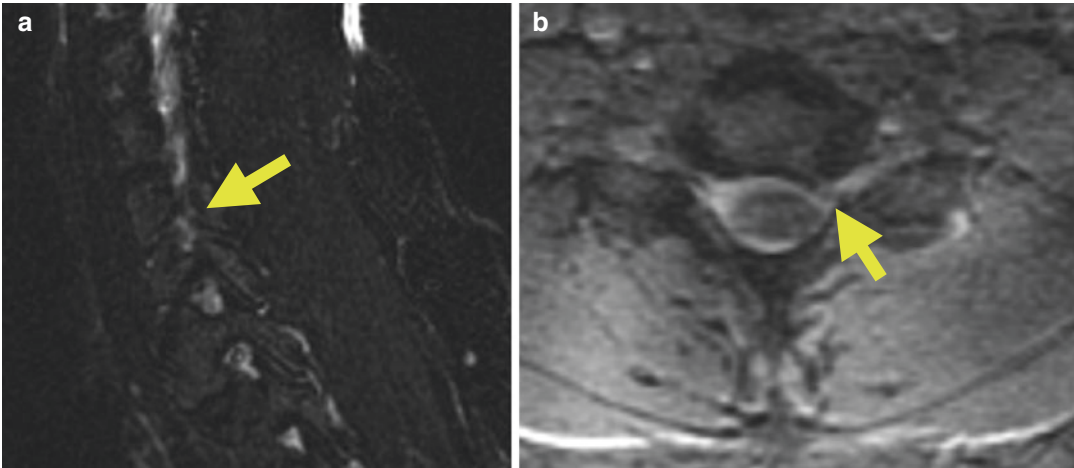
Sagittal (a) and axial (b) T2-weighted imaging of the cervical spine demonstrating a left neural foraminal disk extrusion (arrows)
